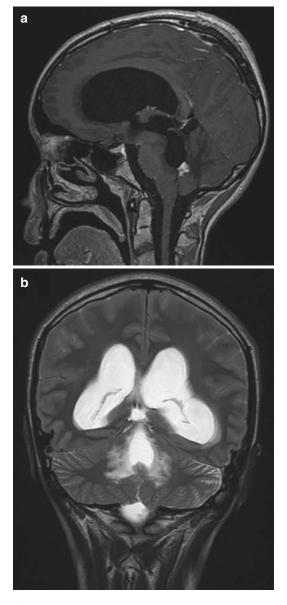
Cerebral MRI in contrast sagittal T1 (a) and coronal T2 (b) views showing a fourth ventricular tuberculoma with an important perilesional edema
